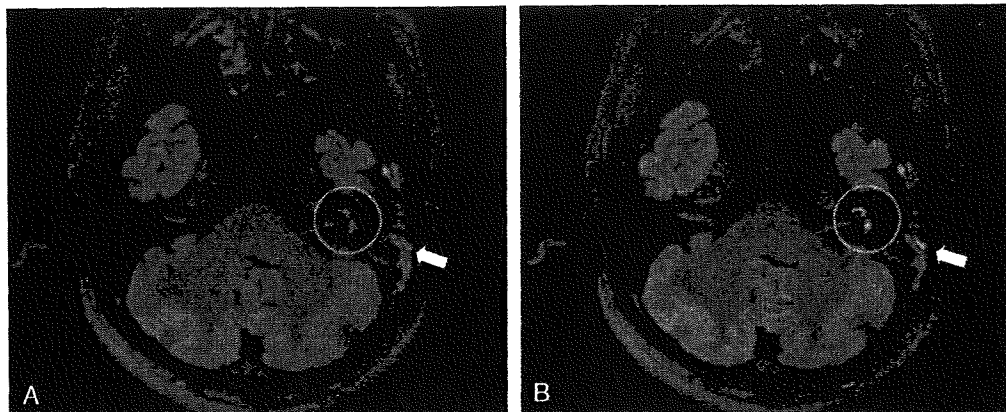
3D-FLAIR images of Case 2. A, B. Pre-contrast (A) and post-contrast (B) middle ear inflammation (arrows) and inner ear lesions (circled).
